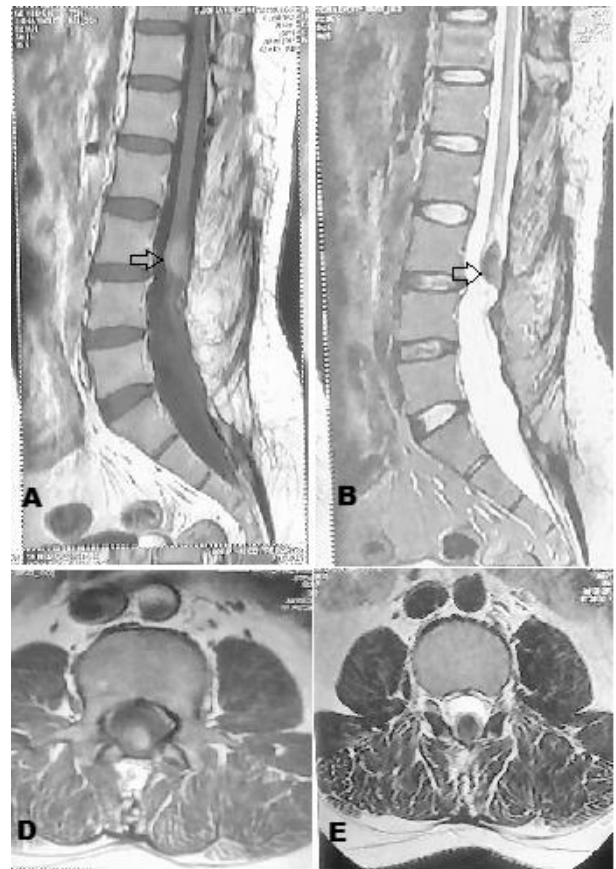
MRI image at eight years follow up shows residual lesion (marked with hollow arrows) opposite the lower half of L3 vertebra which is hyperintense on T1 (A&D) and hypointense on STIR (B & E) indicating fatty tissue. There is no evidence of syrinx.
